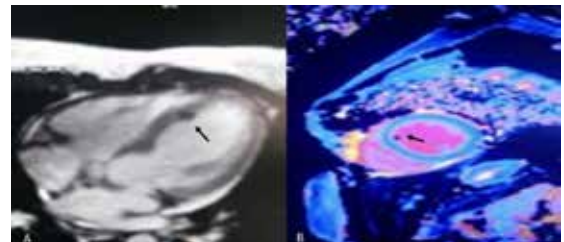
Long axis (A) and fat suppressed cardiac MRI images (B) are showing small lipoma (14x7 mm in diameter) originating from the interventricular septum. Video. Three dimensional echocardiography showing septal lipoma.
